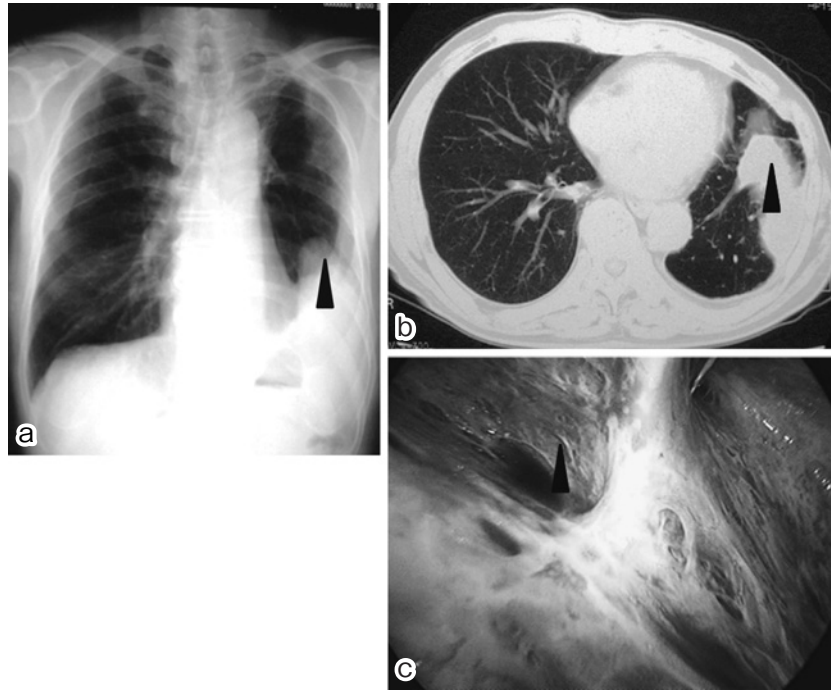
(a) Chest radiography and (b) computed tomography (CT) showed left-sided pleural effusion and diffuse pleural thickening before video-assisted thoracoscopic surgery (VATS) biopsy (second operation). (c) Intraoperative observation showed diffuse pleural thickening without evidence of a solid tumor. (Arrows indicate same areas.)
